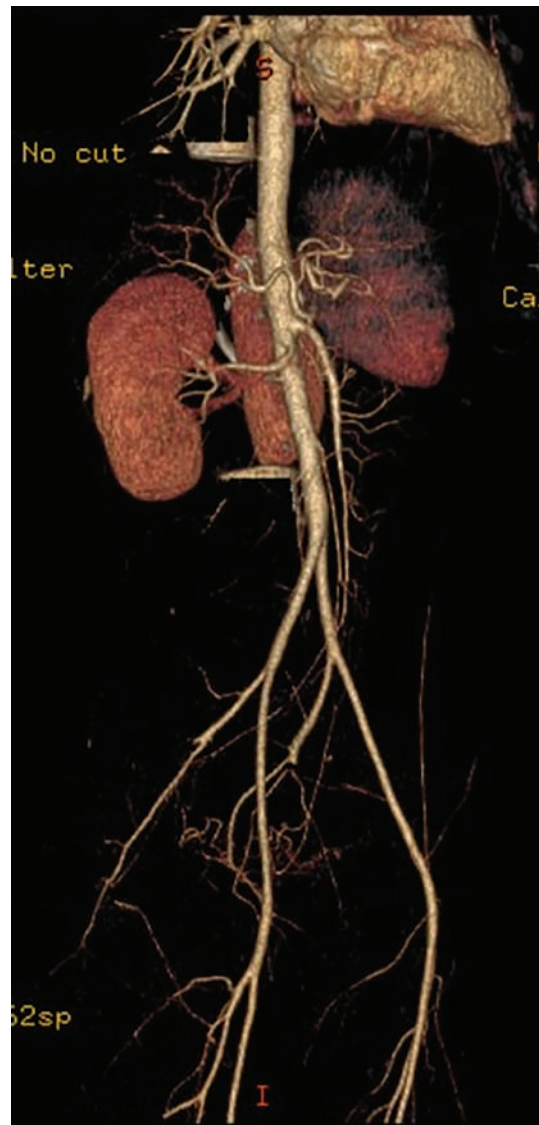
CT angiography image. SMA blood flow appears normal.
